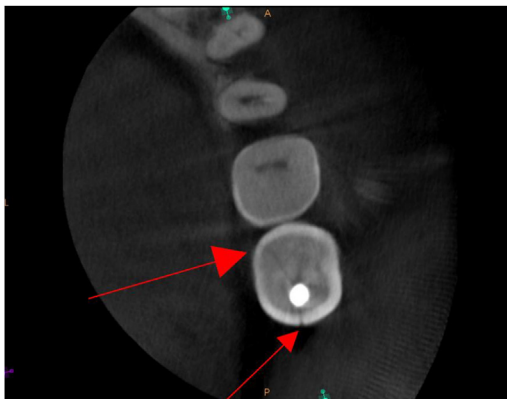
Axial cut of a CBCT scan highlighting a vertical crown root fracture of a mandibular second molar.
